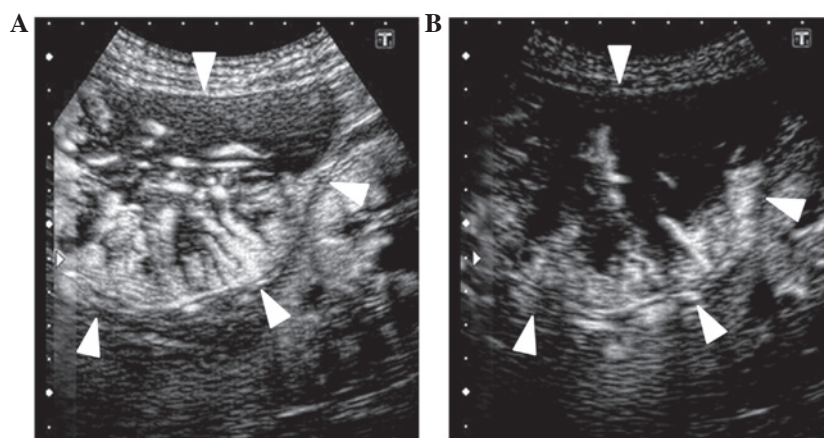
Representative images of the Vd group. The patient was a 70-year-old man with chronic hepatitis C virus. Sorafenib administration (400 mg/day) was started for advanced hepatocellular carcinoma. Contrast-enhanced ultrasonography was performed for giant tumor in S6 (arrowheads) (A) prior to and (B) 4 weeks subsequent to the sorafenib administration. The intratumoral vascular architecture on the micro-flow imaging was narrowed and decreased subsequent to therapy compared with the vascular architecture prior to therapy.
